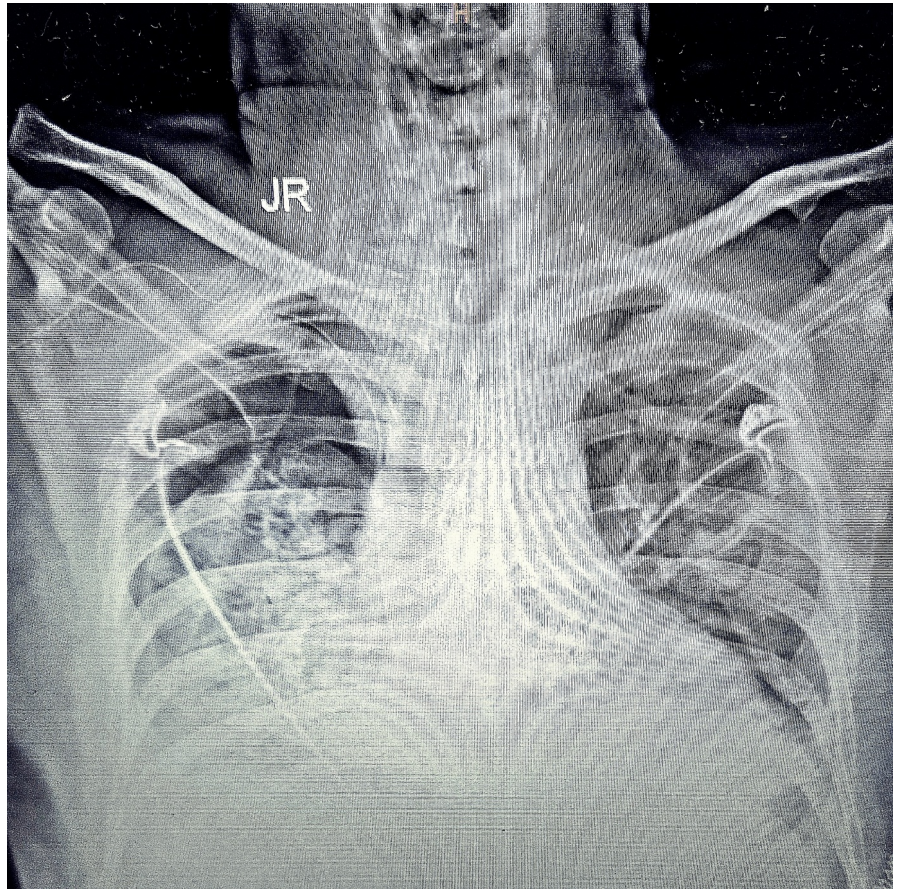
Chest radiograph showing a right-sided hydropneumothorax.
